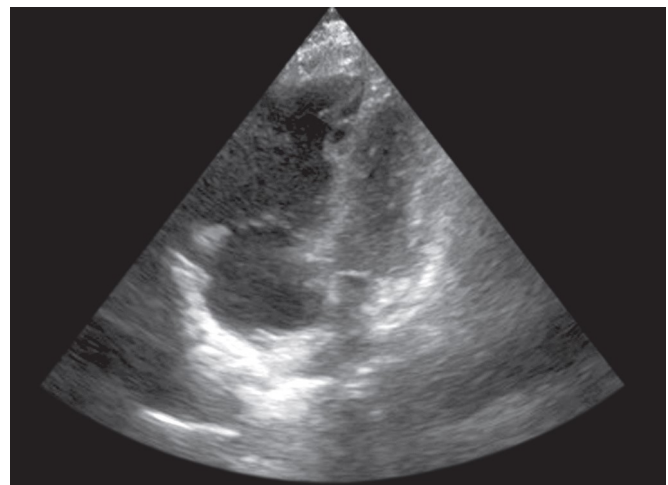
Right ventricle (RV) dilatation in apical four-chamber view.
